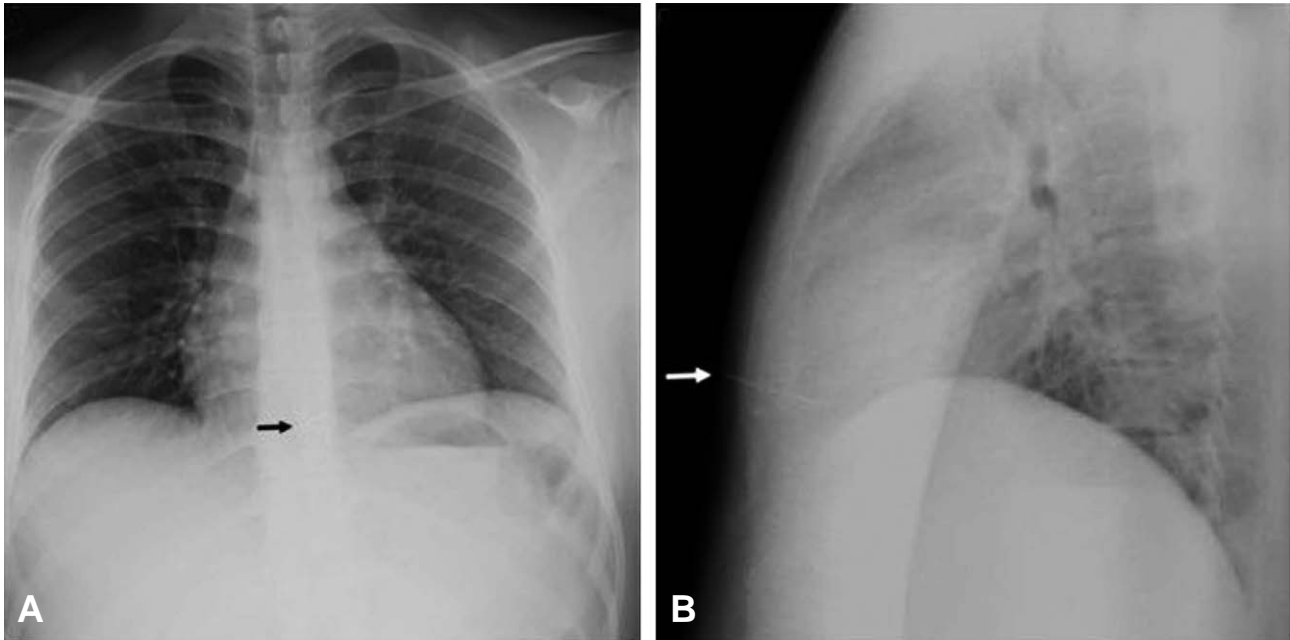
AP (A) and lateral (B) chest radiographs reveal a nail (arrows) penetrating the lower sternum, with the tip pointing towards the heart. On the AP projection, the heart shadow appears enlarged, suggested a possible pericardial effusion.
